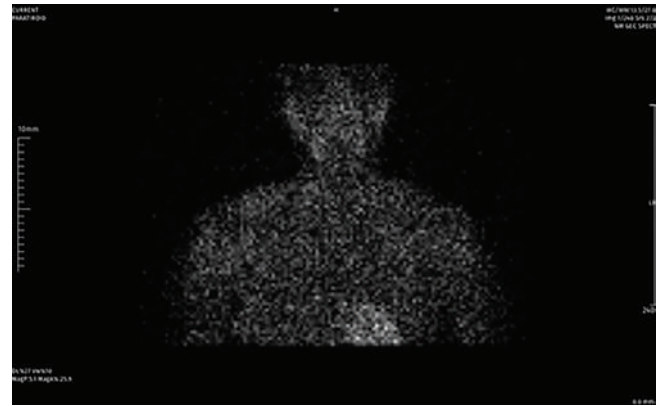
Preoperative Tc-99m MIBI parathyroid scintigraphy.
